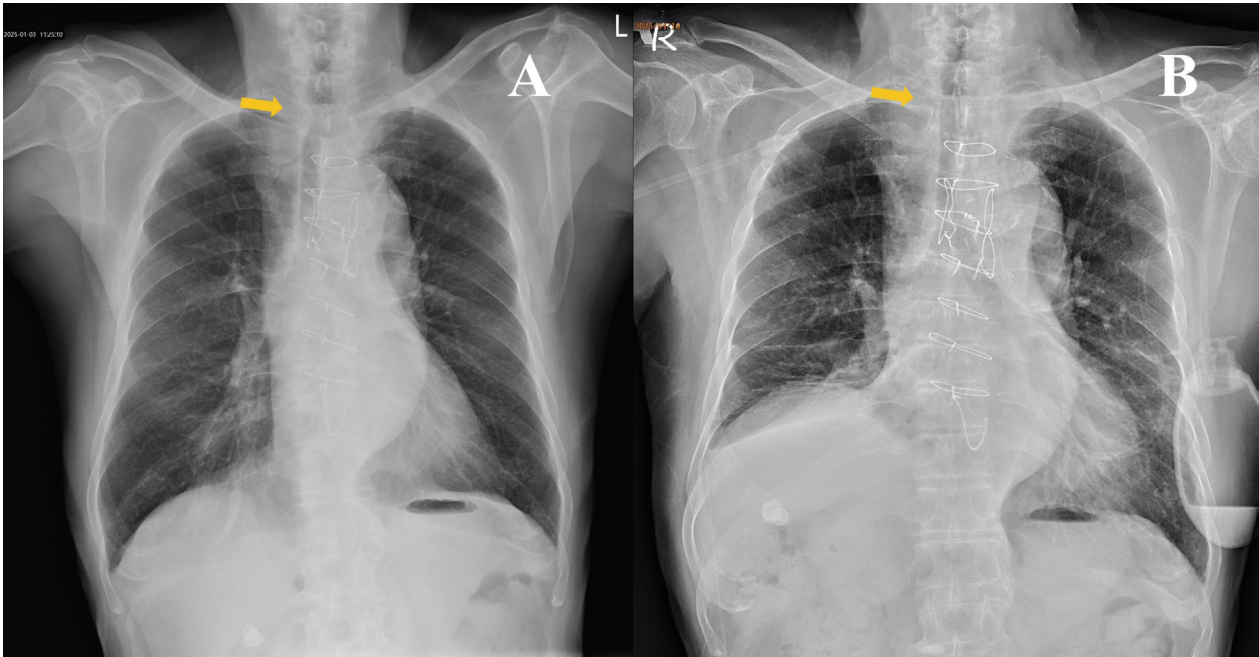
A. Preoperative and B. postoperative chest radiographs revealing improved tracheal patency following cricotracheal resection.
